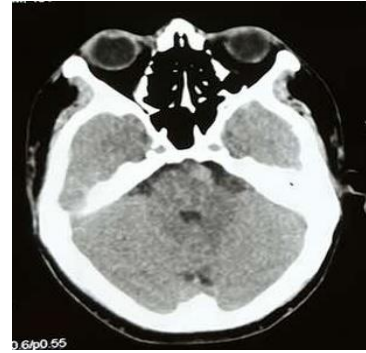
non contrast CT head axial view: Elongated and dilated basilar artery demonstrated in interpeduncular cistern.
